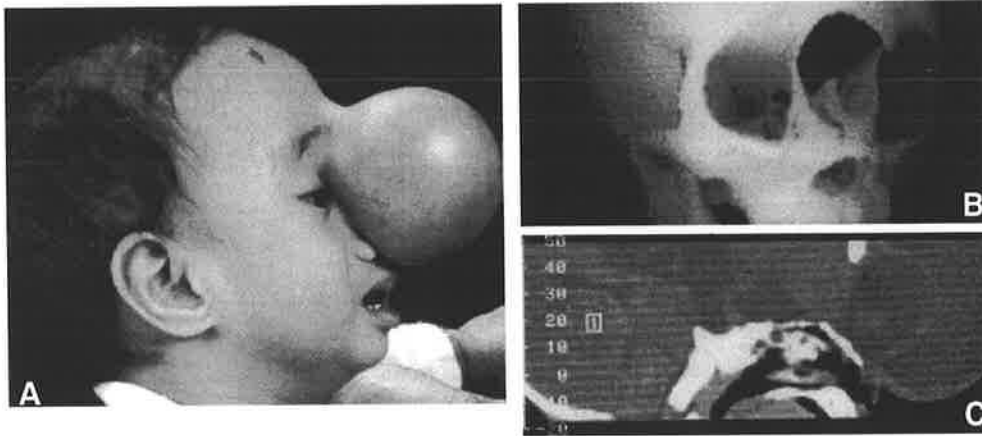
A. A large nasofrontal variety of frontoethmoidal meningoencephalocele. B. A three-dimensional reconstruction of the CT scan shows the facial defect with the nasal bones inferiorly. C. A sagittal section demonstrates the depressed cribriform plate at the base of the bony defect.*
